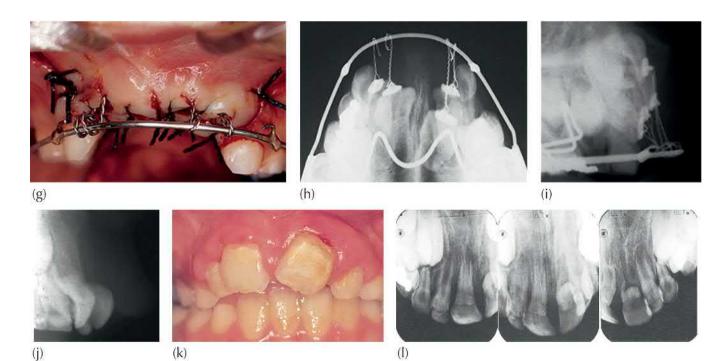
(a) A 9-year-old child has lost alveolar bone height following traumatic avulsion of his anterior deciduous teeth at age 2 years. (b, c) At 9 years of age, the panoramic and lateral cephalograms show very little root development of all maxillary incisors. The central incisors were located at the level of the anterior nasal spine (arrows). (d) Occlusal view of soldered palatal arch. (e) Surgical exposure of the four incisors (note the large areas of hypoplastic enamel). (f) Eyelet attachments bonded. (g–i) The clinical intra-oral and radiographic occlusal and tangential views of the post-surgical condition, showing four twisted ligatures exiting the inferior edge of the fully replaced flap and engaged with the self-supporting labial arch. (j) Radiographic tangential (profile) view across the anterior maxilla, showing the altered developmental anatomy of the damaged teeth. (k) Clinical view of the anterior teeth at the end of phase 1, deliberately excluding mesial uprighting of tooth #21 because it had not developed a root. (l) Long spindly roots the extrusion, but had not developed a root.
